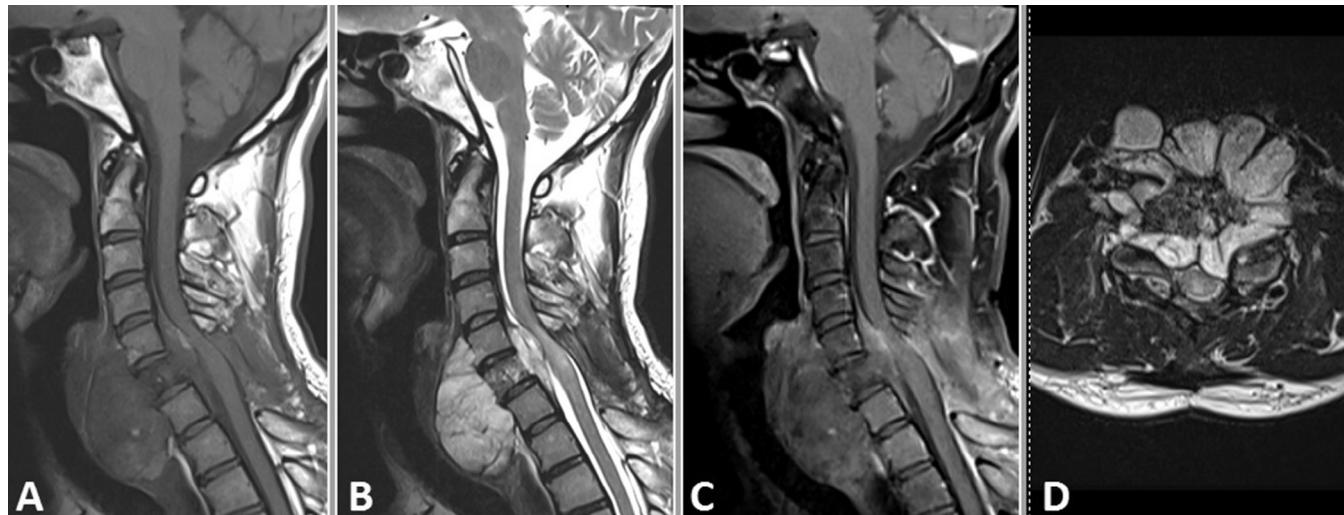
MRI of the cervical spine: (A) Sagittal T1 sequence demonstrating an isointense lesion from C5 to C7 levels with hyperintense areas and epidural and prevertebral components. (B) The lesion is noted to be hyperintense on T2-weighted sequences. (C) Mild enhancement with contrast is noted on gadolinium-enhanced T1 sequences. (D) Axial T2 sequence demonstrating a multilobulated appearance of the lesion.
